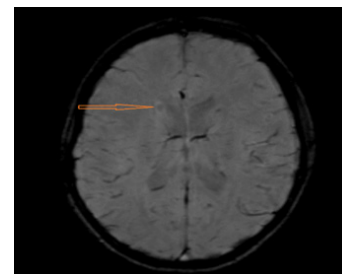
The MRI brain scans (A, B, C) were T2 dark fluid images that showed an incidental connatal cyst to the frontal horn with no significant interval changes from the previous study (January 2024).
